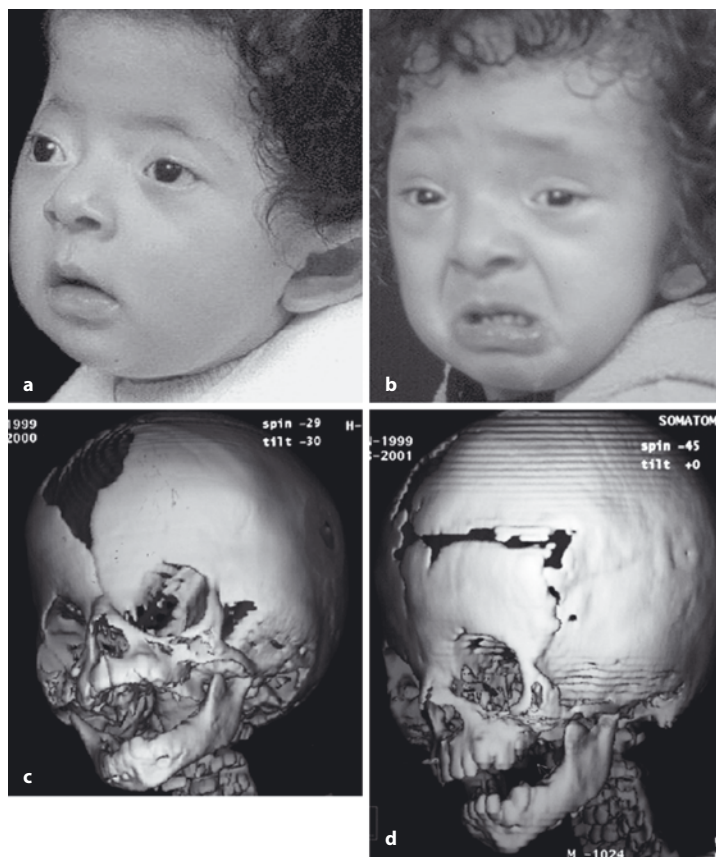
a–d. a Pre-operative third quarter view of a 14 months old girl with Apert Syndrome showing a severe supra-orbital depression, fronto-orbital deformity and midface retrusion. b Post distraction clinical changes. The “true monoblock” has corrected frontal deformity, exorbitism and midface retrusion. Oxygen saturation is normal during sleep. c A preoperative CT scan of a 14 months young girl with Apert Syndrome, brachycephaly with a severe flattened supra-orbital region is observed together with severe midface retrusion. Oxygen saturation drops during the sleep of the patient. d Post distraction CT scan shows the new position of the mid-face with the simultaneous correction of the orbits position and the frontal bone after a “true monoblock” advancement. New bone formation is observed in the lateral aspect of the frontal bone, in the lateral orbital wall, the zygoma and at the pterygomaxillary area. On the frontal bone an extra remodeling is observed in the patient during the consolidation period. The brain expansion force produce a round shape on the frontal bone achieving a structure very closely to the normality
